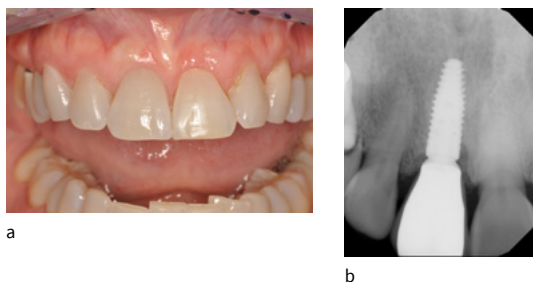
Right-central incisor replaced with an implant-supported crown on a platform-switched bone level implant in a patient with high esthetic risk. a: Facial view showing maintenance of labial contour and interdental papillas. b: Radiograph showing excellent crestal bone maintenance
